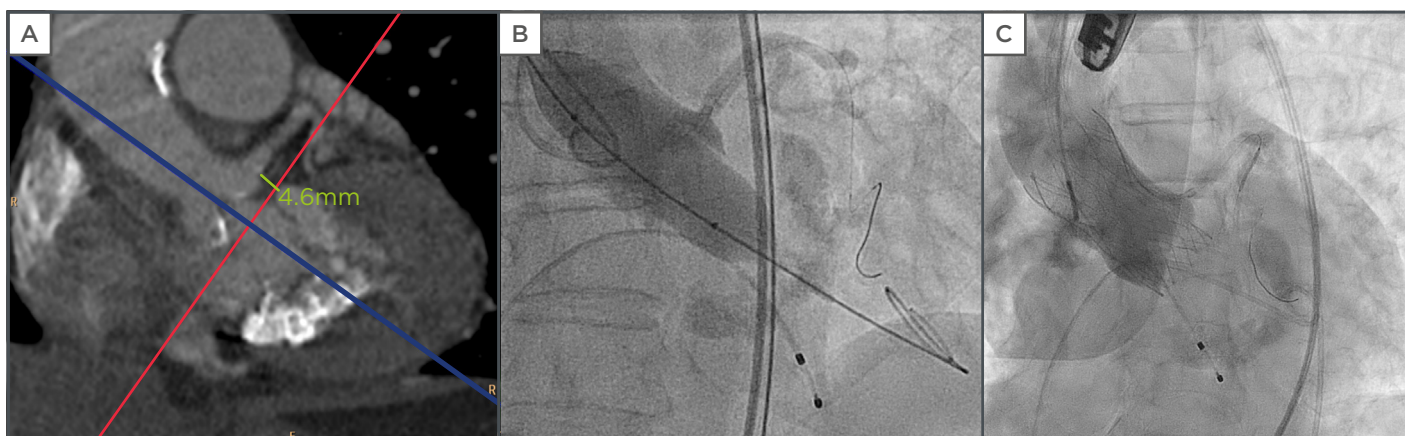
A) Multidetector computed tomography (CT) scan showing the LMCA height of 4.6 mm; B) certifying normal flow through the coronary arteries during balloon inflation; C) controlled valve release and LMCA protection system.
